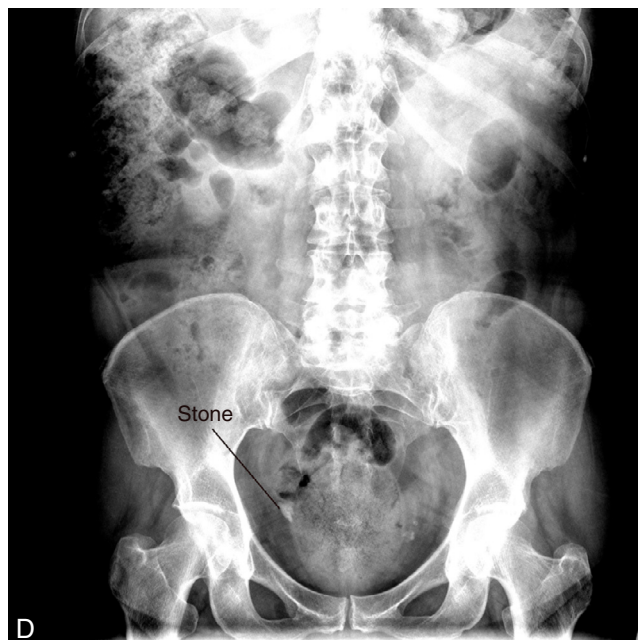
Plain X-ray of the preoperative image.
